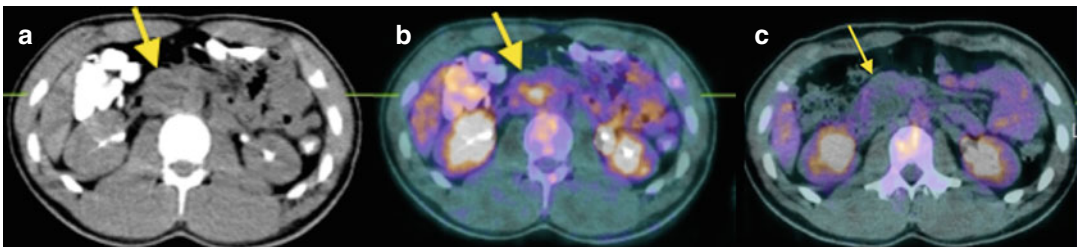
Recurrent non-seminomatous germ cell tumor. A 10-year-old male with a past history of previous right orchidectomy for non-seminomatous germ cell tumor. Routine follow-up blood tests showed increasing hCG and AFP. (a) CT scan (axial slice) shows a low-density mass in right para-aortic region at the renal hila level. (b) Fluorine-18-FDG PET/CT shows increased metabolic
